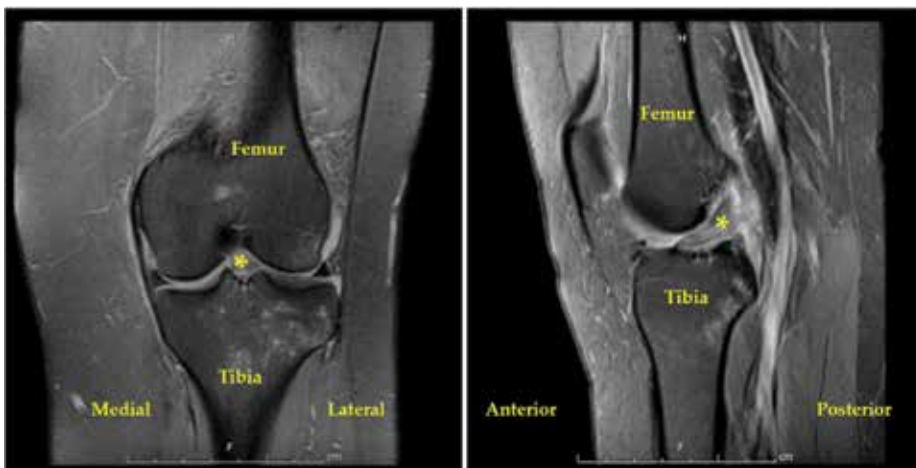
Preoperative MRI of the patient with ACL deficiency of the left knee reveals the increased signal intensity in the ACL fibers with the presence of a loose ACL remnant (yellow asterisk, *). The hypersignal of the lateral tibial plateau is represented by a valgus-impacted injury with bone bruise.
